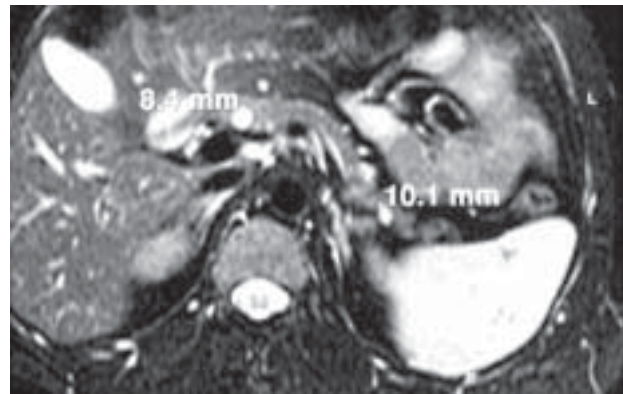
Magnetic resonance imaging of the pancreas revealing 2 pathological lesions
